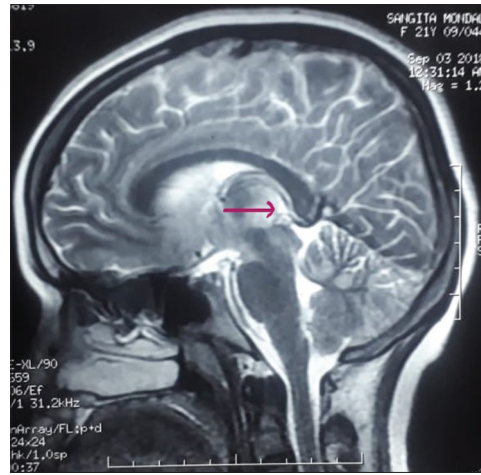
Cerebral MRI brain showing FLAIR hyperintensity of the mammillary body (pink arrow) which is also quite specific for WE
